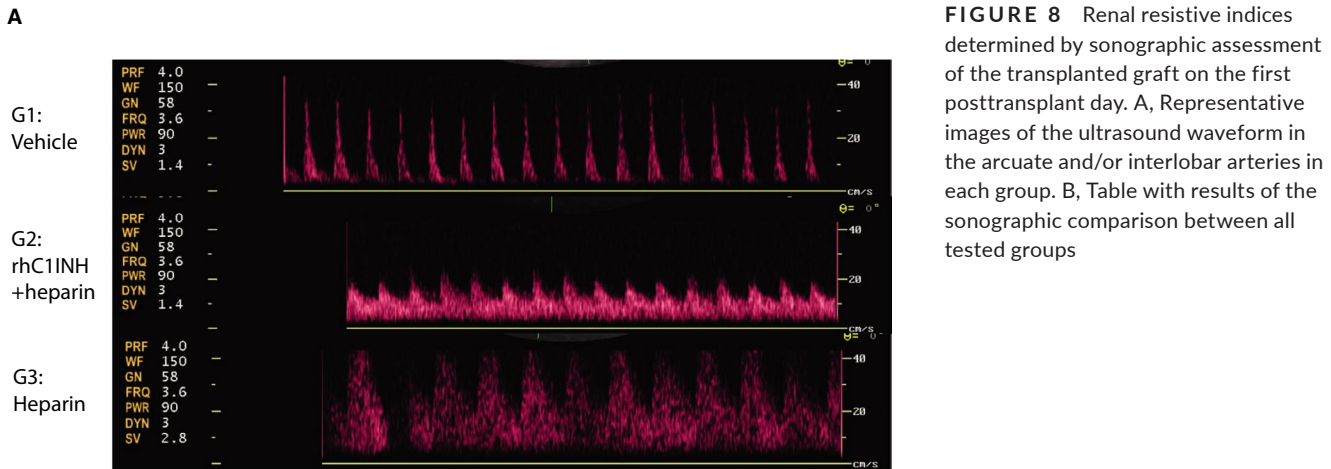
Renal resistive indices determined by sonographic assessment of the transplanted graft on the first posttransplant day. A, Representative images of the ultrasound waveform in the arcuate and/or interlobar arteries in each group. B, Table with results of the sonographic comparison between all tested groups
